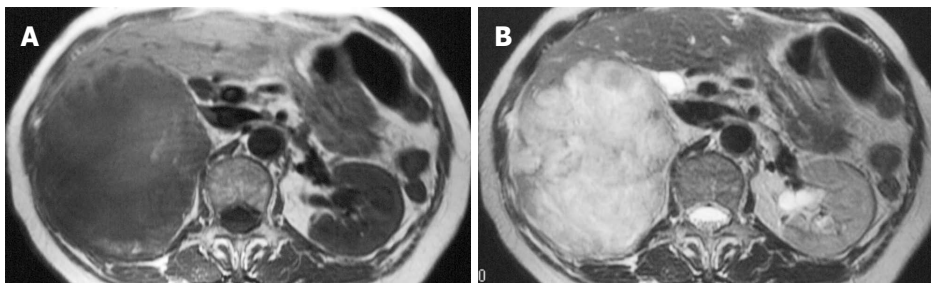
Magnetic resonance imaging showing hypointense areas in the right lobe of the liver on a T1-weighted image (A) and an inhomogeneously hyperintense mass on a T2-weighted image (B).
